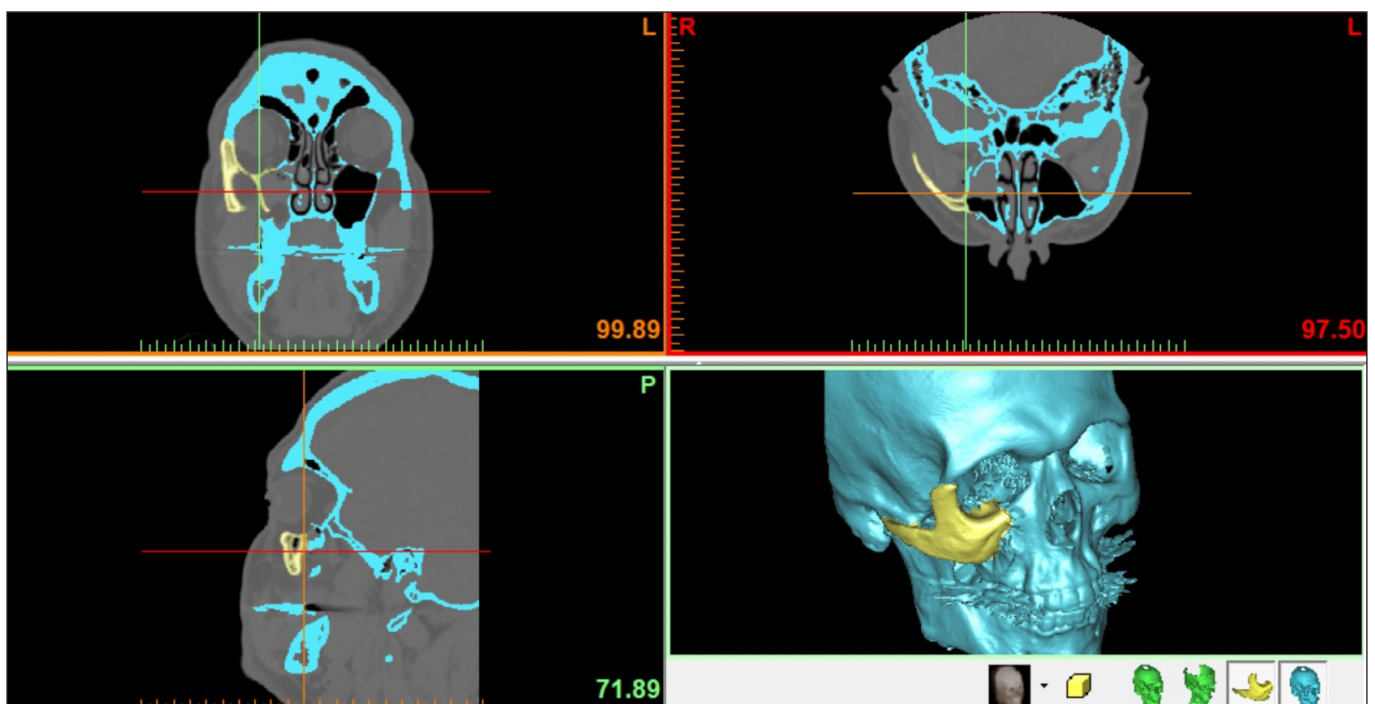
Virtual 3D data obtained with maxillofacial CT DICOM data.
